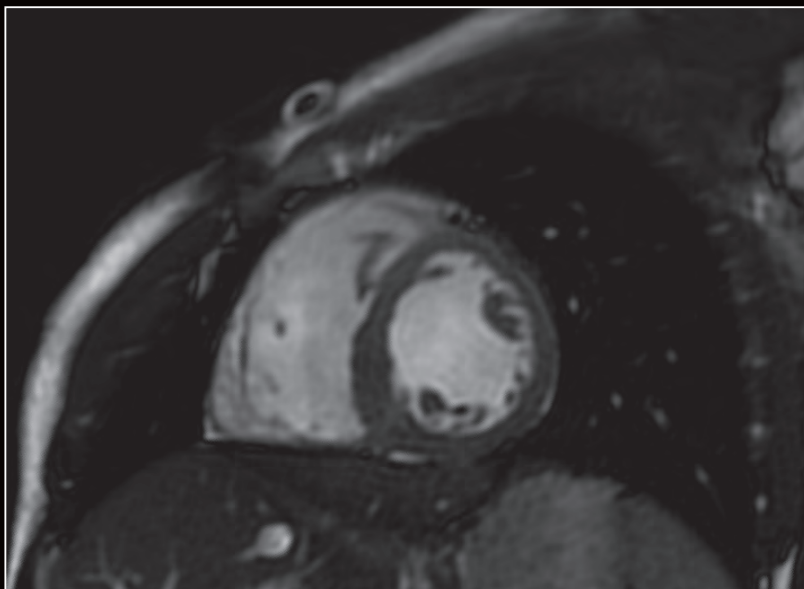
Short axis 2D FIESTA. The combination of SIGNA™ Premier and AIR Technology™ delivers high SNR and high image quality for excellent cardiac MR imaging results at 3.0T.
